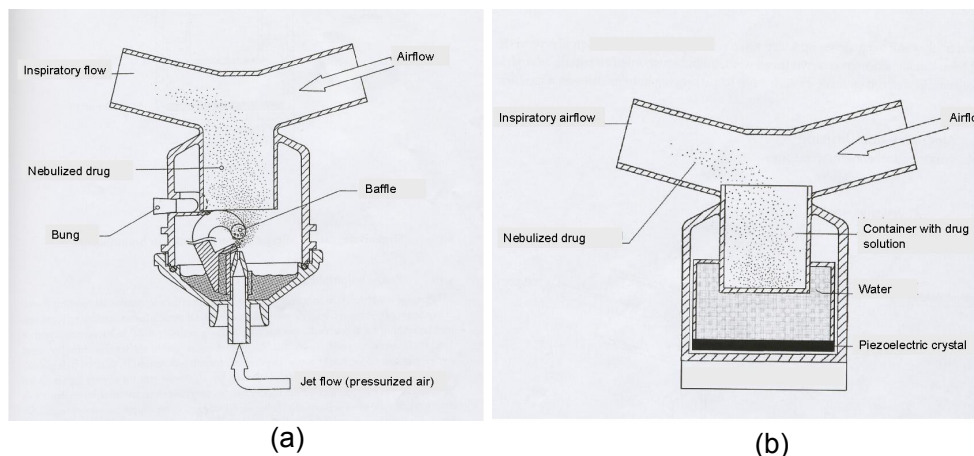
Cross-section of : A. Jet nebulizer; B. Ultrasonic nebulizer (78)
